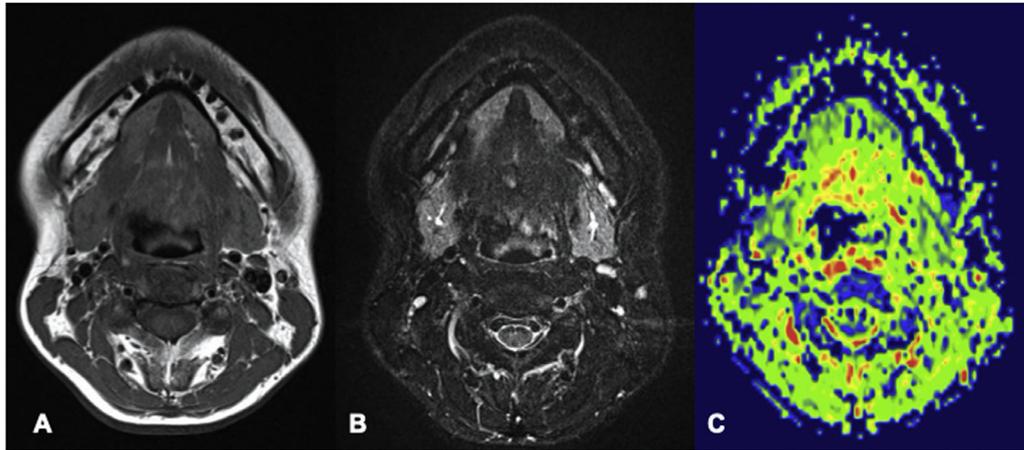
A 37-year-old woman complaining of pain in the salivary gland region with a duration of 4 months, but no imaging alteration. (A) T1-weighted axial slices. (B) T2-weighted short tau inversion recovery (STIR) axial slices. (C) Its correspondent apparent diffusion coefficient (ADC) map.
